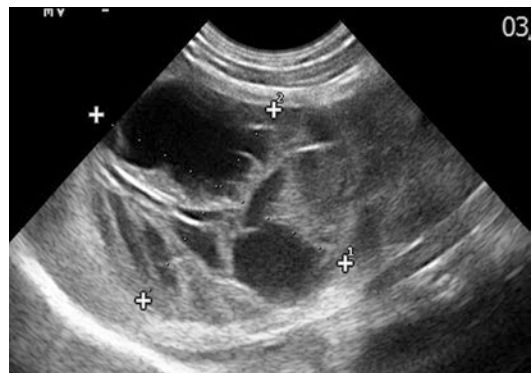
Ultrasound shows an intermediate stage adrenal hematoma: the gland is enlarged (calipers) with complex aspect, due to the presence of echoic mixed with anechoic zones
